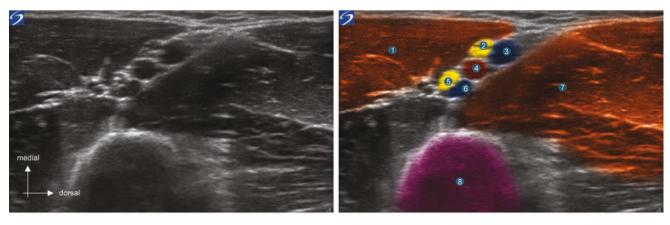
Section of arm in the brachial canal with materialisation of the ultrasound bundle
